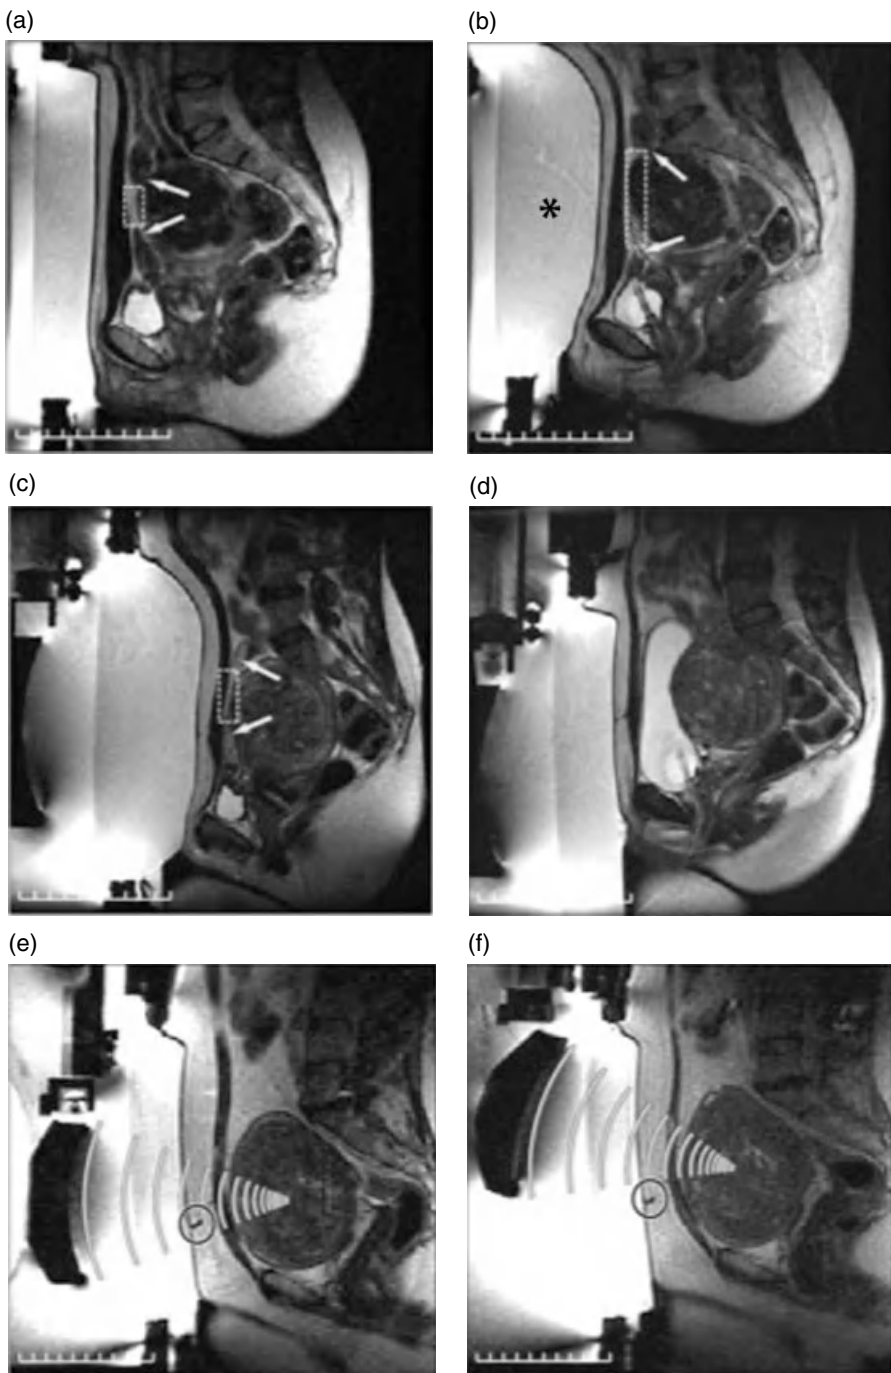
Challenging treatment planning scenarios. (a) In this patient, bowel loops in front of the fibroid (*arrows*) initially reduce the acoustic window (*box*). (b) To move these loops aside, a larger gel pad is placed below the abdomen (*), increasing the acoustic window, and allowing most of the fibroid to be accessible. (c) In another patient, even with this larger gel pad, bowel loops in front of the fibroid (*arrows*) still severely limit the acoustic window (*box*). (d) Normal saline is instilled into the urinary bladder via a Foley catheter, which displaces the bowel loops and creates a much larger acoustic window. (e) The third patient has a scar directly in front of the fibroid (*circle*). (f) By tilting the ultrasound beam, the scar can be avoided. Reproduced from Shen et al. (2009) with permission from Elsevier.
